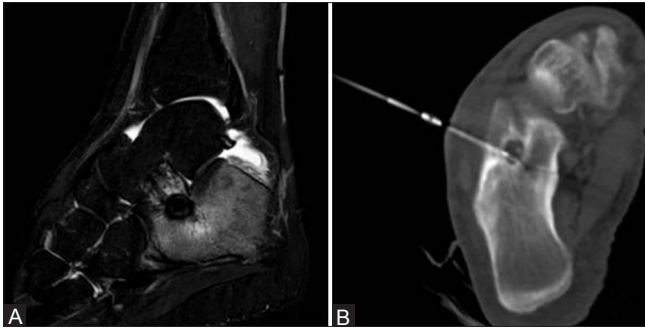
(A and B): A 17-year-old boy with a right calcaneal osteoid osteoma near the talocalcaneal joint margin. (A) Magnetic resonance imaging (STIR) sagittal image shows central nidus surrounded by hypointense reactive sclerosis. Rest of the surrounding calcaneum appear hyperintense due to reactive edema due to osteoid osteoma. (B) CT scan shows RFA probe *in situ* in nidus
